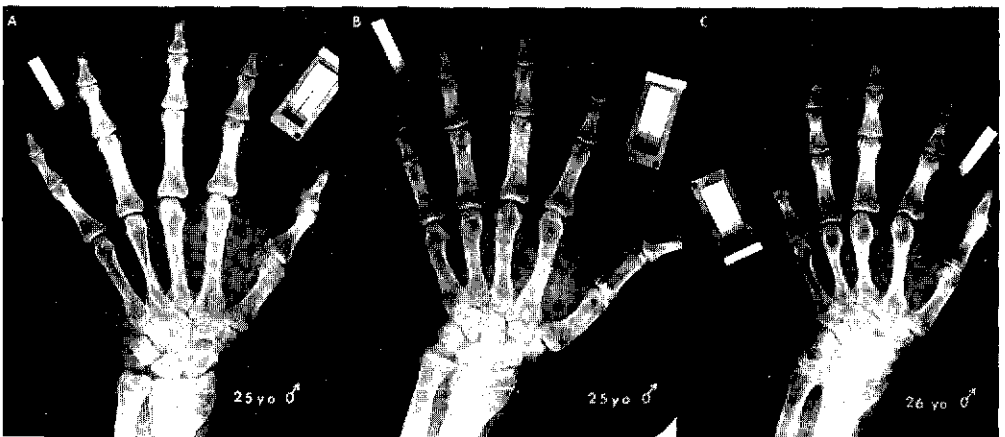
Two adult cretins (A and C) compared with a goitrous non-cretin of similar age (B). It is noteworthy that the hand x-ray on the right (C) displays severe shortening of the metacarpals while the cretin on the left (A) shows hand development comparable to the non-cretin (B). The cretin with the hand deformity is dwarfed while the cretin with normal hand configuration is non-dwarfed.
